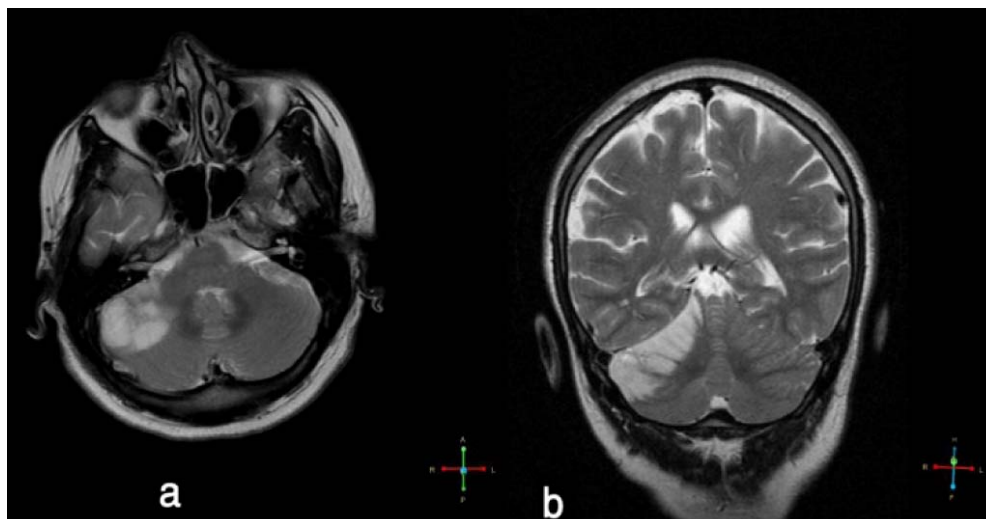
Axial (a) and coronal (b) views of T2 weighted Magnetic Resonance Imaging of the brain show right side cerebellar infarction.
